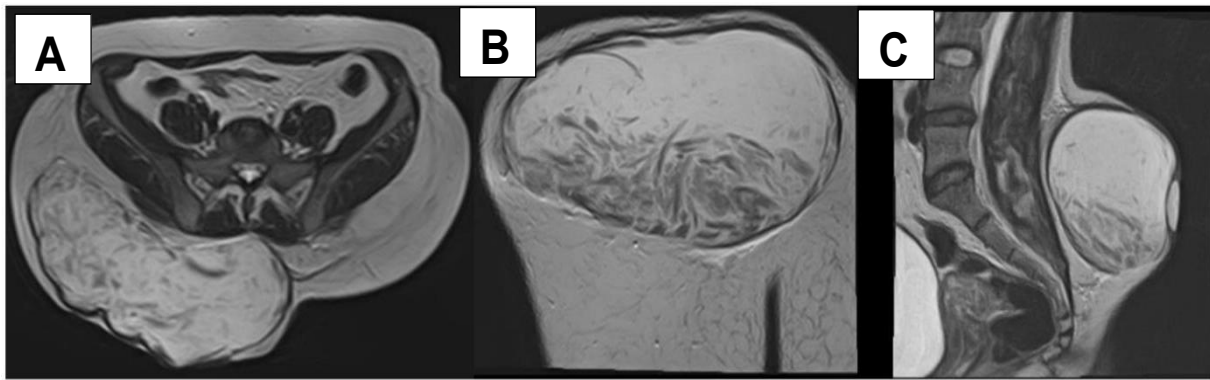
(A) axial, (B) coronal, (C) sagittal. MRI T2 weighted image of right gluteal giant epidermal cyst shows a hypointense, large well demarcated mass with hypointense filiform debris within the dependent region of the mass suggestive of giant epidermal cyst.
